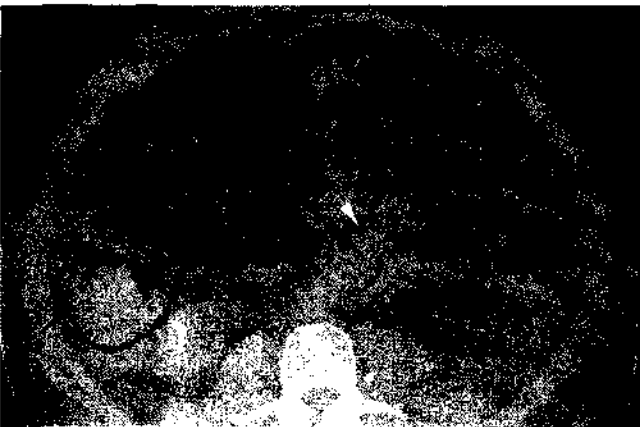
Axial abdominal CT image with contrast. Pneumatosis is present throughout the dilated large and small bowel (arrowheads) in this 45-year-old male with ischemic bowel secondary to infection. The patient was admitted and treated with antibiotics. Clinically, the patient improved and was eventually discharged home.
